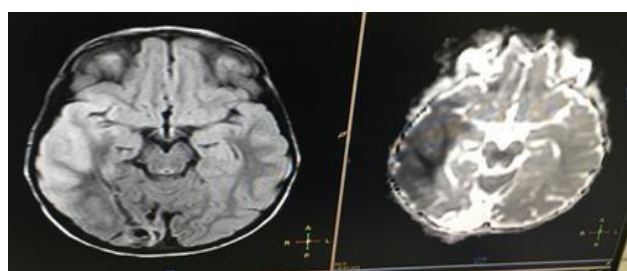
MRI brain showing ischaemic changes in the brain.
